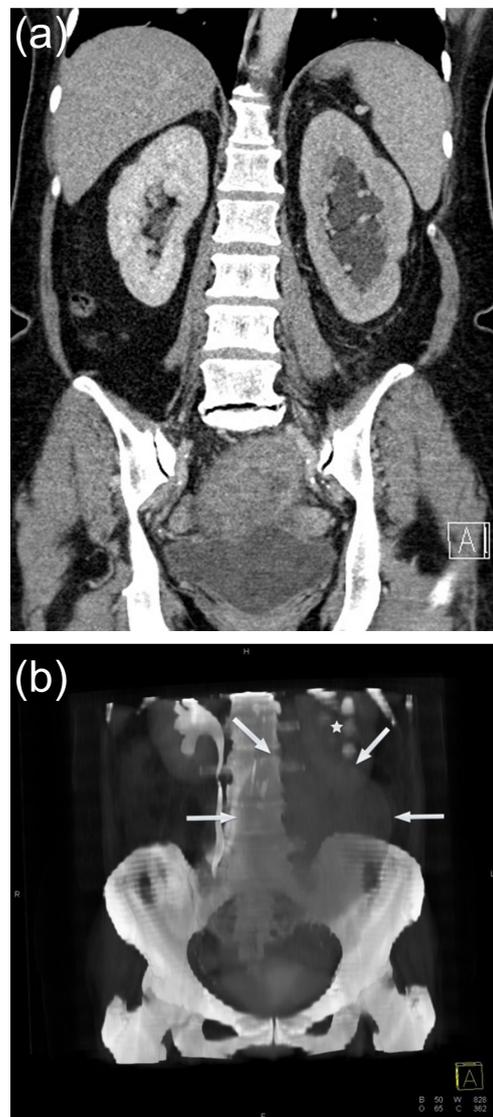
(a) Coronal CT abdomen and pelvis with contrast and (b) 3D reformatted image. Left gonadal vein leiomyosarcoma outlined by arrows in (b) compresses and obstructs left ureter resulting in left hydroureteronephrosis and delayed contrast excretion (star in (b)).
